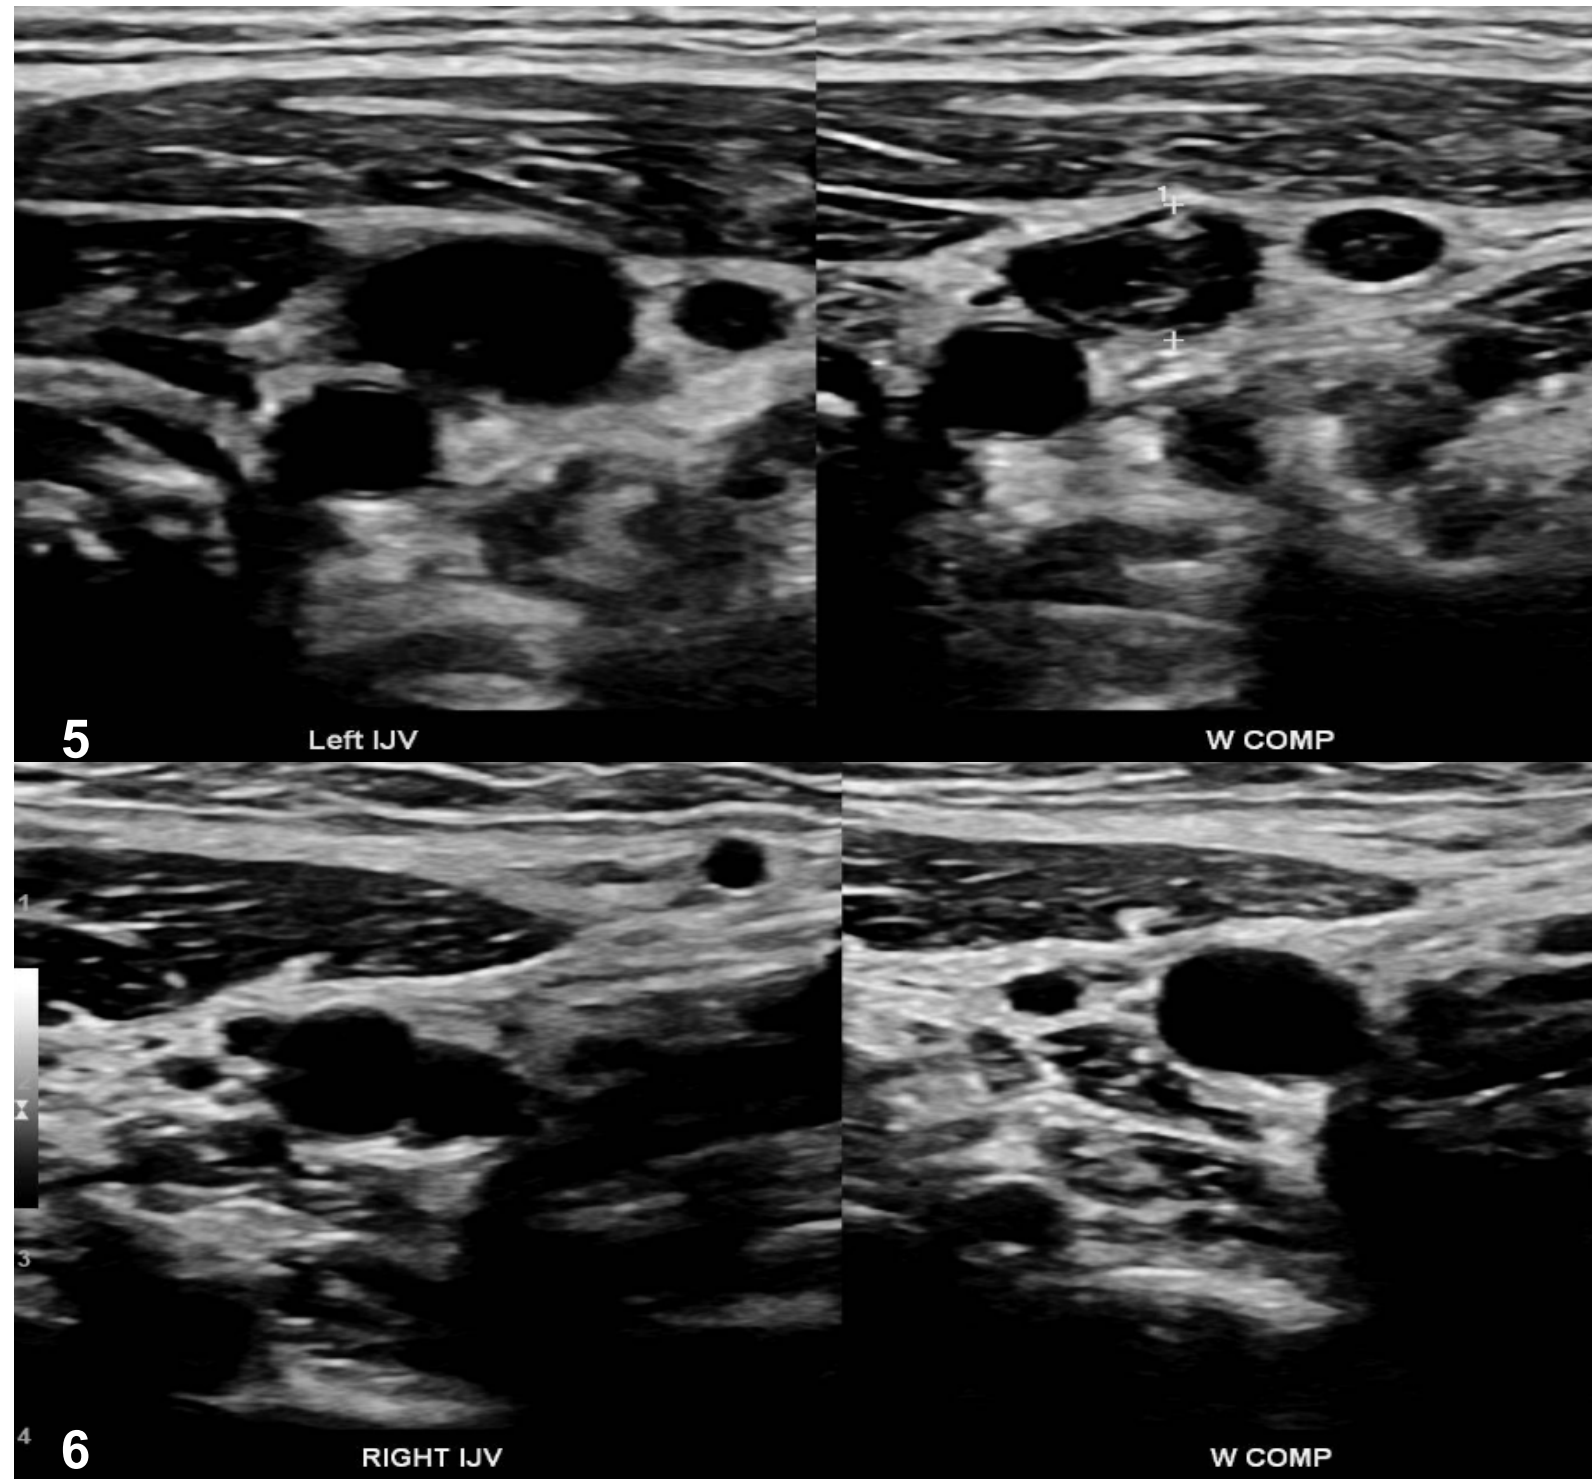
Doppler ultrasound with acute thrombus in left internal jugular vein (IJV).
